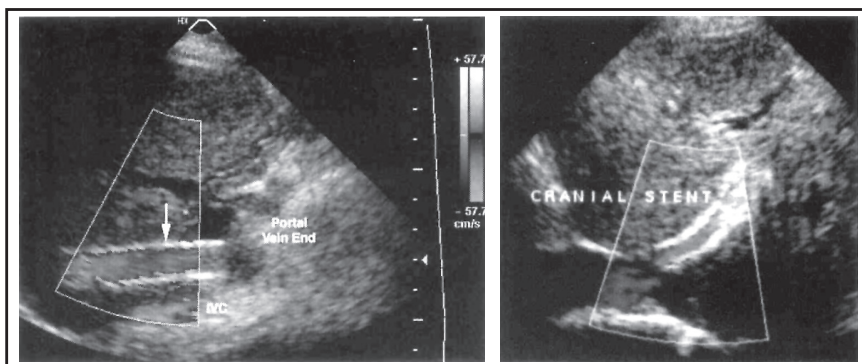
Ultrasound: TIPS Stent
